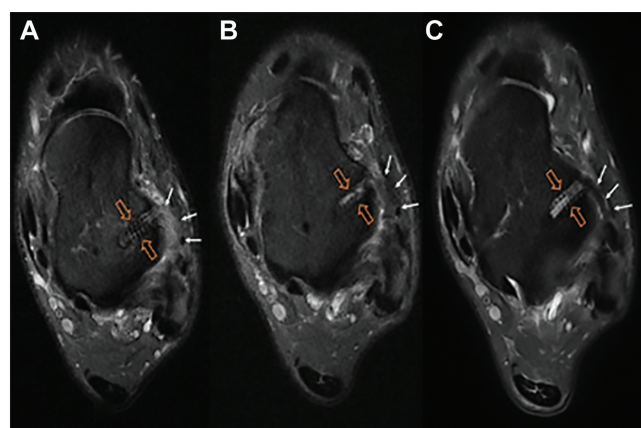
Proton density–fat suppressed weighted sequence with axial ankle view at (A) 6, (B) 12, and (C) 24 months after anatomic lateral ankle ligament reconstruction showing the morphological/signal magnetic resonance imaging evolution of the ATFL graft—ATFL graft (white arrows) and talar tunnel (large open arrows). ATFL, anterior talofibular ligament.
